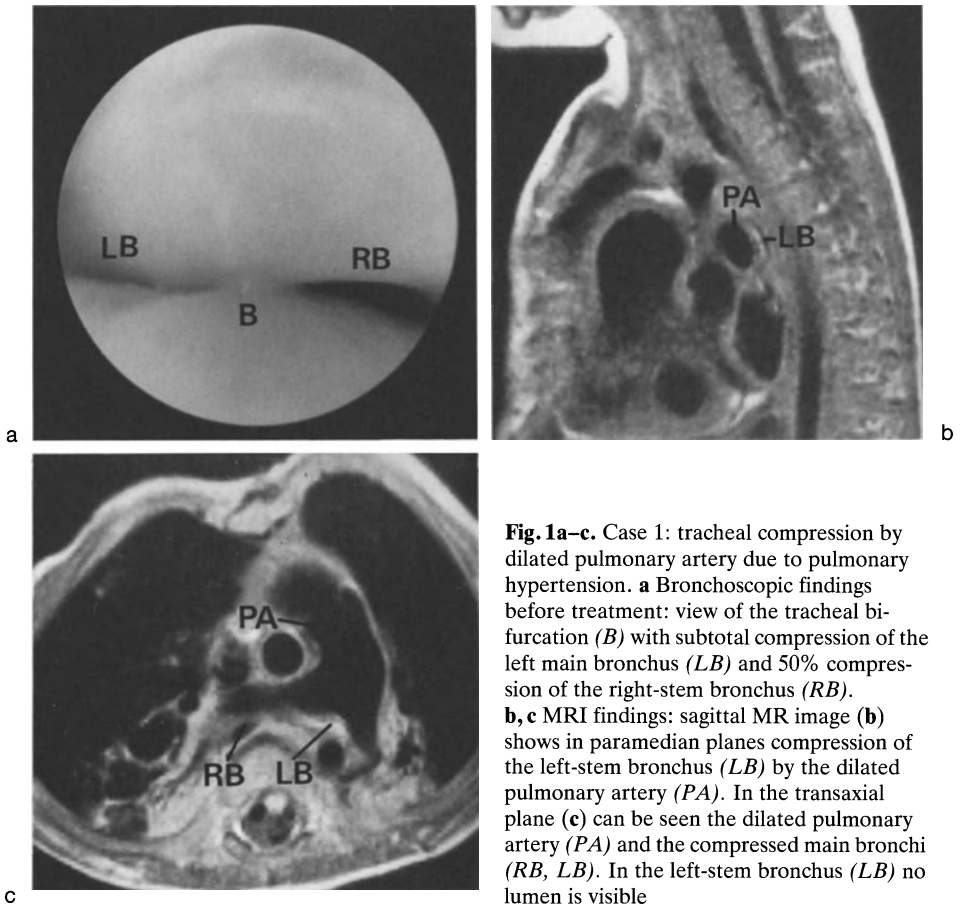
Case 1: tracheal compression by dilated pulmonary artery due to pulmonary hypertension. a Bronchoscopic findings before treatment: view of the tracheal bifurcation (*B*) with subtotal compression of the left main bronchus (*LB*) and 50% compression of the right-stem bronchus (*RB*). b, c MRI findings: sagittal MR image (b) shows in paramedian planes compression of the left-stem bronchus (*LB*) by the dilated pulmonary artery (*PA*). In the transaxial plane (c) can be seen the dilated pulmonary artery (*PA*) and the compressed main bronchi (*RB, LB*). In the left-stem bronchus (*LB*) no lumen is visible
